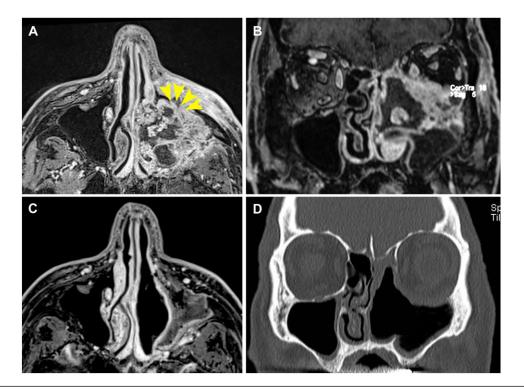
Preoperative axial (A) and coronal (B) magnetic resonance imaging with contrast enhancement showing the persistence of a left maxillary squamous cell carcinoma (case 1) eroding the anterior wall of the sinus (yellow arrows) without soft tissue involvement. Postoperative contrast-enhanced magnetic resonance imaging with axial view (C) demonstrates the radical resection of the tumor. The isointense signal on the surgical bed is compatible with scar tissue related to the surgical procedure, given the lack of contrast enhancement uptake. The postoperative coronal CT scan (D) highlights the removal of the bony orbital floor and the inferomedial angle of the orbit (left side). Herniation of the orbital content and the enophthalmos are avoided by preserving the periobital layer.
